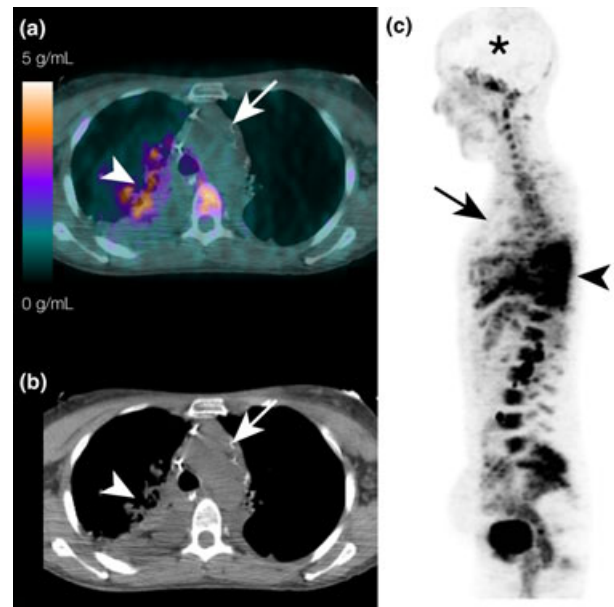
(a) Fused PET/CT axial view and (b) corresponding CT view showing the residual mediastinal mass (arrow) with no significant ^{18}F -FDG uptake (standardized uptake value = 1.1 g/ml). An active right basal pneumonia that had developed within 48 h since initial CT survey was evidenced with an increased ^{18}F -FDG uptake affecting mainly the right lower lobe (arrowhead). (c) PET maximum intensity projection view failed to evidence any increased mediastinal uptake (arrow). Note the absence of ^{18}F -FDG uptake in the anoxic brain (*), but the presence of increased ^{18}F -FDG uptake in the right inferior lobar infection (arrowhead) and in the axial skeleton in relation to bone marrow stimulation.
